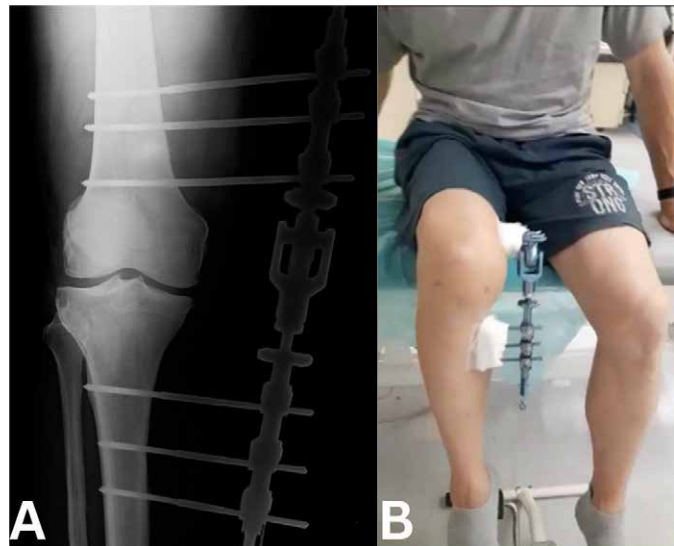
X-ray of the distraction device with separated articular surfaces of the medial compartment of the knee (A) and native photo of the patient during rehabilitation with 90 degrees of flexion of the knee (B) (Fig. by Mislav Jelić) (34,35)
